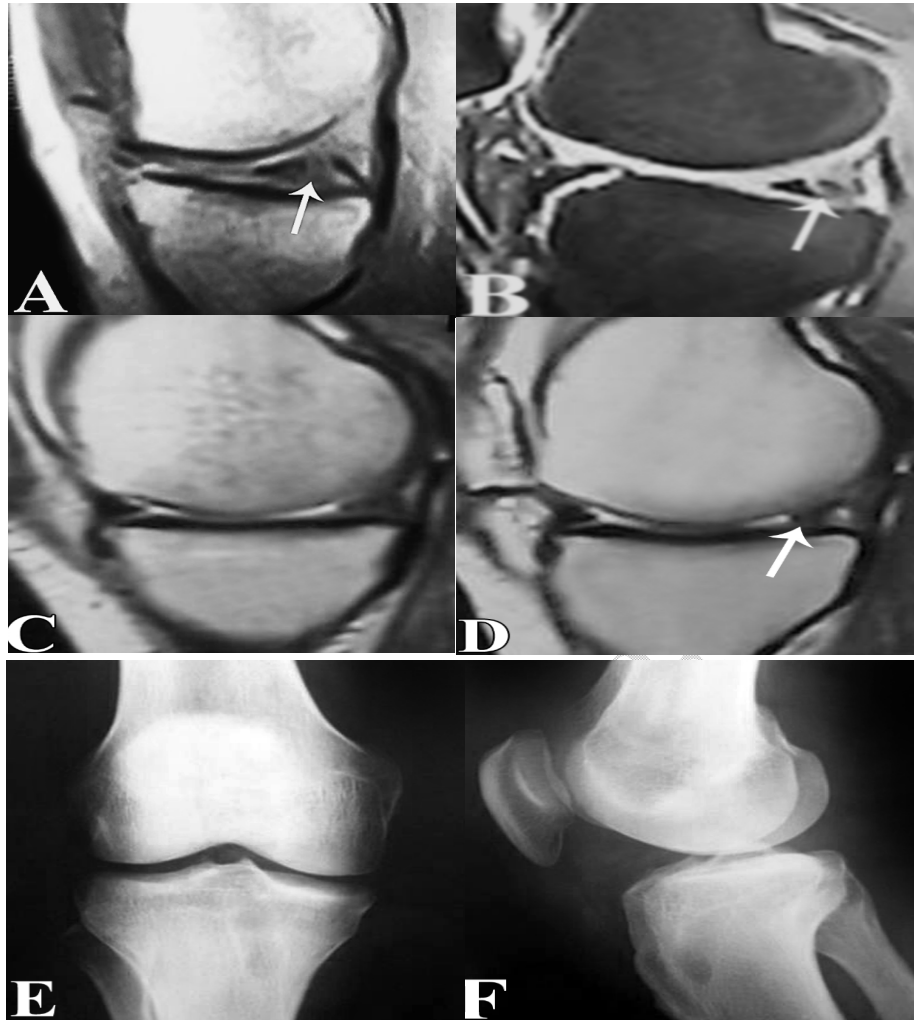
Pre-operative MRI, Post-operative MRI, and Post operative Plain x ray of knee
